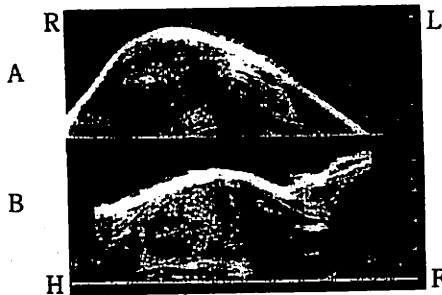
Ultrasonography shows a hypoechoic solid mass in the right lobe of the thyroid. Trachéal deviation toward the left side is apparent. (A) : Transaxial, and (B) : sagittal scan. R : right, L : left, H : head, F : foot.
